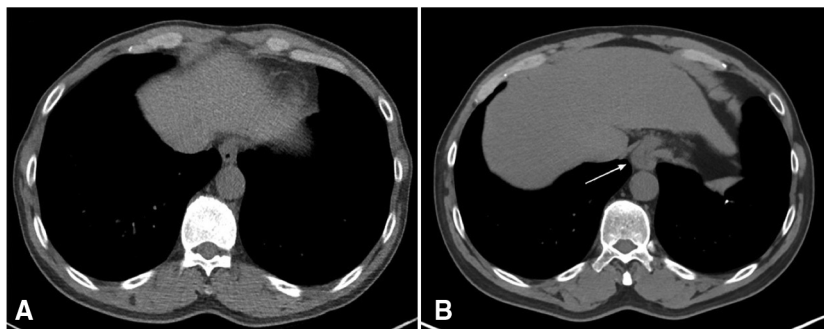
Preoperative (A) and postoperative (B) CT scans, 52 months apart, showing a new HH (arrow) after wedge resection of a 1-cm left lower lobe adenocarcinoma.
